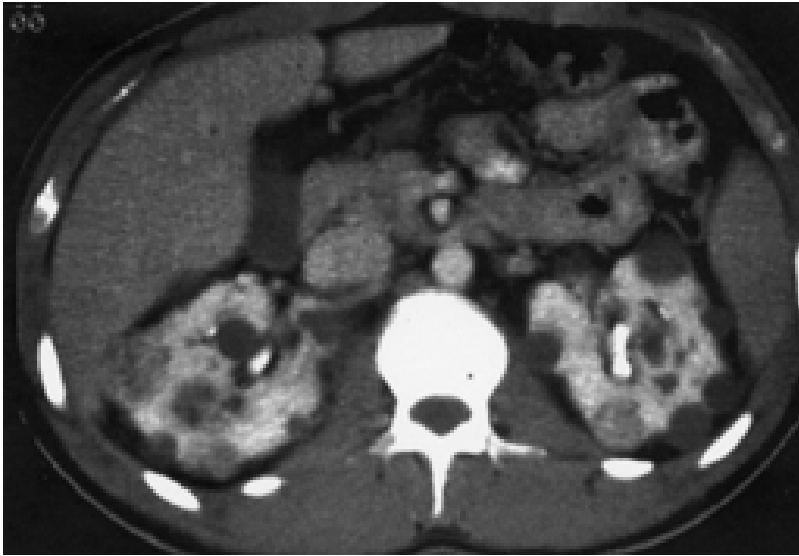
Abdominal computed tomography of renal masses in a patient with Von Hippel-Lindau disease.
